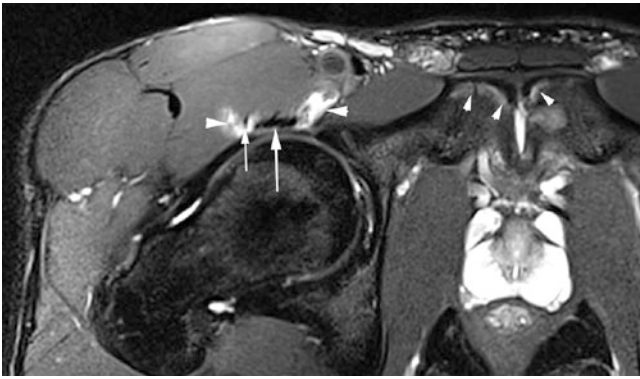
Iliopsoas bursitis. A 23-year-old soccer player with right-sided pain. Axial T2FS MR image shows marked edema and bursitis (arrowheads) surrounding both the psoas (large arrow) and iliacus (small arrow) components of the iliopsoas tendon anterior to a normal hip joint. Note the normal pubic apophyses (small white arrowheads). (Reproduced with permission from reference Madani H, Robinson P. Top-Ten Tips for Imaging Groin Injury in Athletes. *Semin Musculoskelet Radiol.* 2019;23(4):361–75.)
